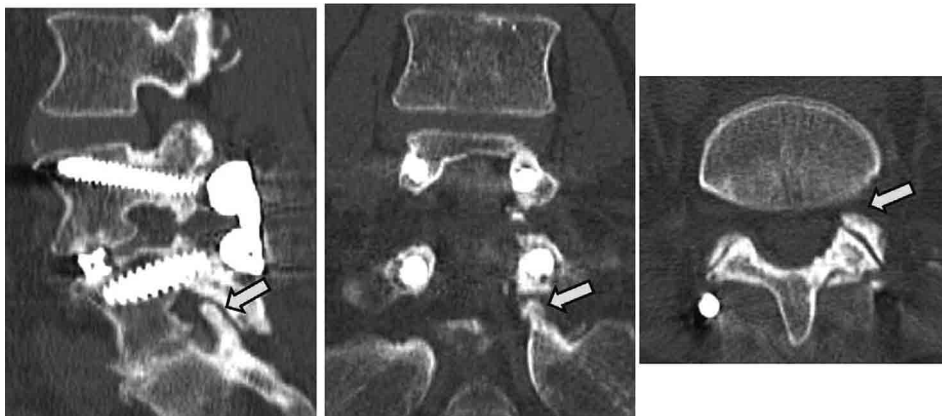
CT scans before percutaneous endoscopic lumbar foraminoplasty. Computed tomography scans show left bony foraminal stenosis at the level of L5/S. There is an obvious protruding bone at the ventral aspect of upper articular process of the sacrum (arrow).
